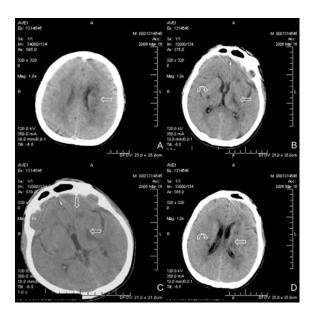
CT scan of the brain revealed acute cerebral infarction at the left corona radiate (A and D), internal capsule (B and C) (horizontal arrow) and frontal lobe (C) (vertical arrow) and old cerebral infarction at posterior limb of right internal capsule (B and D) (curved arrow)
